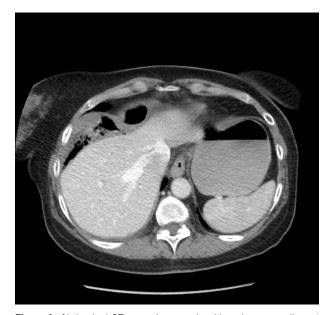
Abdominal CT scan shows malpositioned cecum adjacent to the right lobe of liver.
